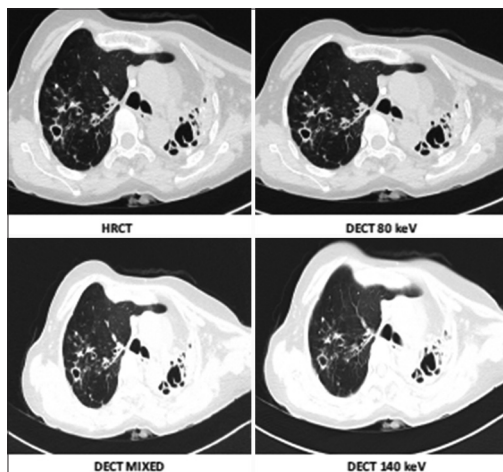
A 65-year-old man who presented with cough and weight loss with diagnosis of pulmonary tuberculosis. Axial high-resolution computed tomography (CT) and contrast-enhanced dual-energy CT (80 keV, mixed, and 140 keV) images showing cavity with surrounding nodules (few of these nodules are calcified) in the right lung and collapsed left lung with bronchiectatic changes and few calcified nodules. A large calcified lymph node is noted right paratracheal region.
